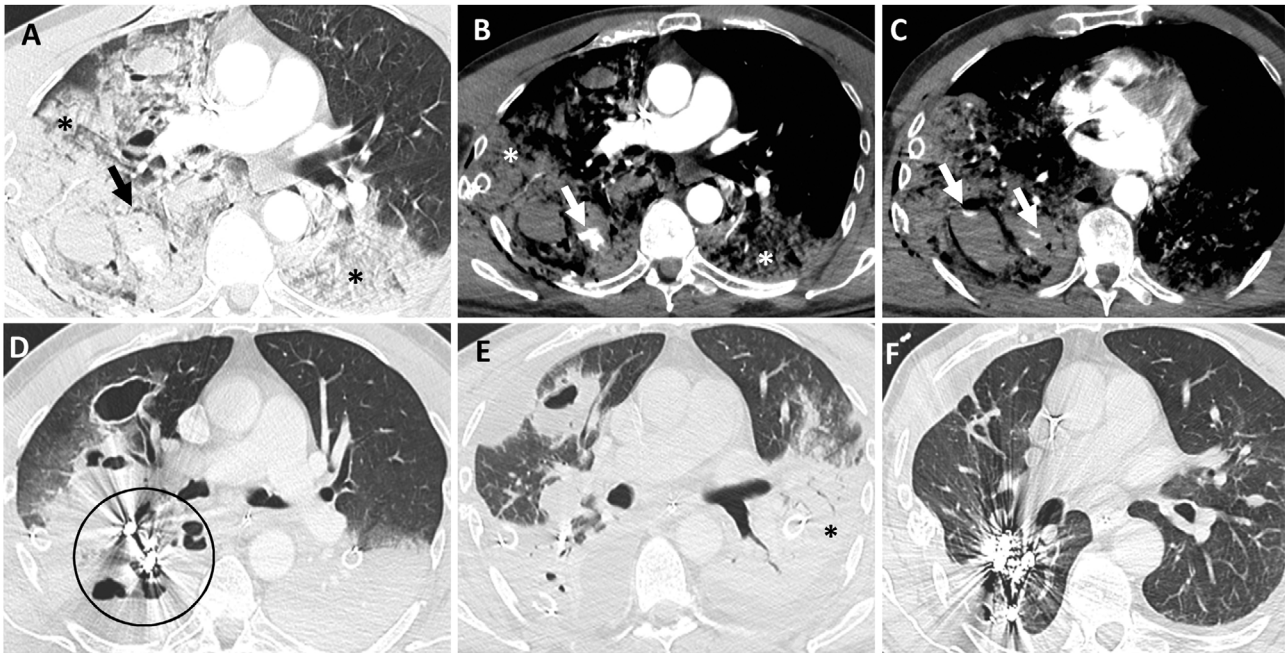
58-year-old pedestrian hit by a car. A-C) The images in the top row (axial chest CT images in lung window [A] and mediastinal window [B and C]) show several right pulmonary haematoceles in which foci of active bleeding (arrows) and extensive bilateral pulmonary contusions (asterisks) are observed. This complication is rare and was treated with embolisation of several pulmonary arteries. D-F) Bottom row images (axial chest CT images in lung window) obtained at four days (D), three weeks (E) and two months (F) after the trauma show the embolisation material (circle in D) and the progressive decrease in size of the haematoceles. Note the appearance of pneumonic consolidation in the left lung (asterisk in E), a relatively frequent complication in this type of patient.
